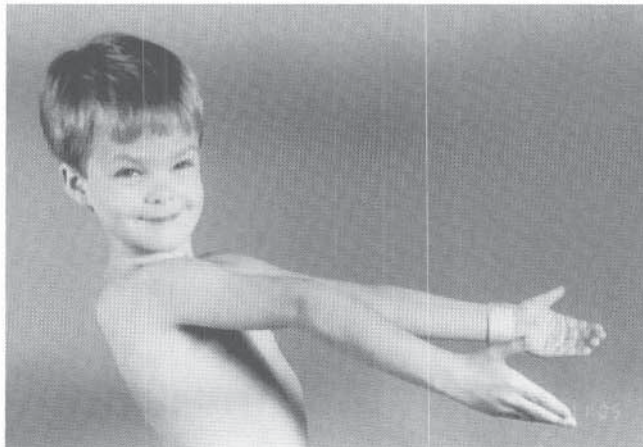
Medial opening wedge osteotomy to correct cubitus varus. A, Preoperative radiographs showing varus malunion with hyperextension. B, Preoperative clinical appearance. Note the significant hyperextension component of the deformity.
